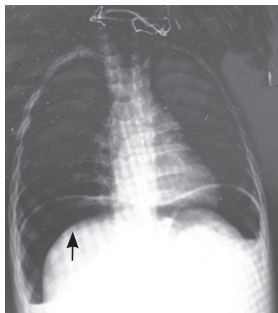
Abdominal X-ray showing bilateral subphrenic free gas.
